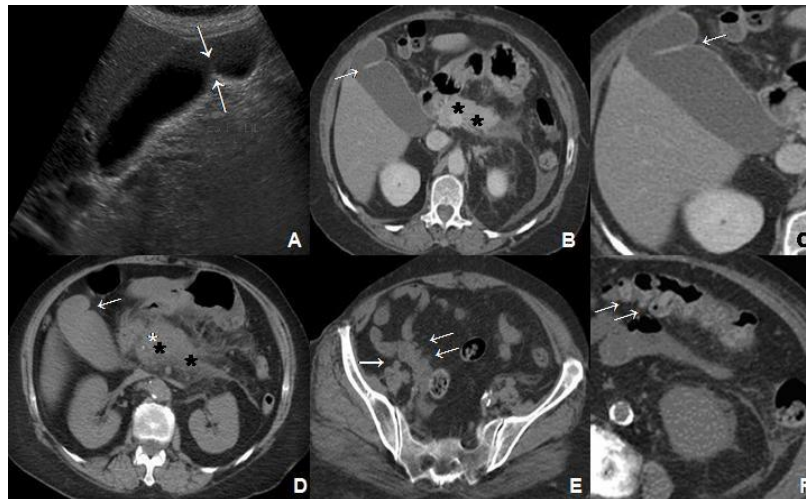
A: Ultrasonography of abdomen showing a septae between the body and the fundus of gallbladder (arrows), which causes a “Phrygian cap” aspect; B and C: CT of abdomen done during a previous episode of pancreatitis, showing the Phrygian cap anomaly (arrows) and the changes of pancreatitis (stars); D: Phrygian cap gallbladder (arrow), diffuse increase of pancreatic volume (stars) and of the density in peripancreatic fat, mainly in the body and tail, and thickening of perirenal space detected by CT in present admission; E and F: diverticulosis (arrows) observed in colonic segments
